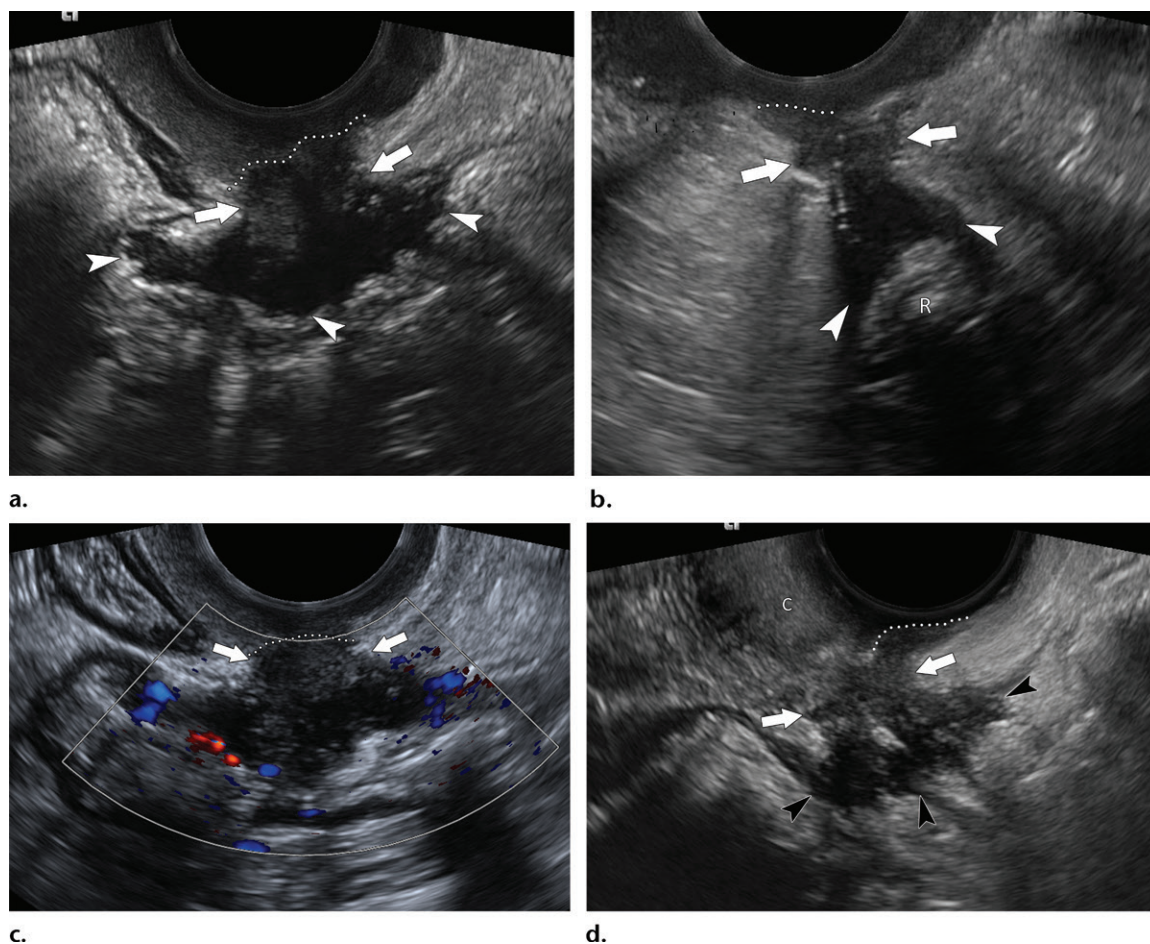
Rectovaginal DIE in two women. (a–c) Sagittal (a) and transverse (b) gray-scale, and color Doppler (c) TVS images in a 43-year-old woman with a history of severe endometriosis with nodules and adhesions, who presented with increasing pelvic pressure and dysuria several years after undergoing a hysterectomy and no vaginal lesions at speculum examination, show hypoechoic thickening of the lower anterior rectum (R) (arrowheads in a and b), with extension into the RVS (arrows) and posterior vaginal wall (dotted line). (d) Sagittal gray-scale TVS image in a 46-year-old woman with chronic bilateral lower pelvic pain and cramping, a history of stage IV endometriosis, and multifocal multicentric bowel DIE (same patient as in Figure 8c and 8d) shows an additional rectal nodule (arrowheads), with extension to the posterior vaginal fornix (arrows). The patient had focal tenderness in this area during TVS. C = cervix.
